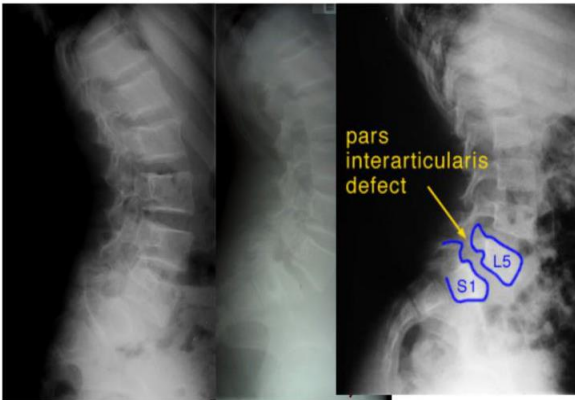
AP and Lateral X-rays of the Spine
